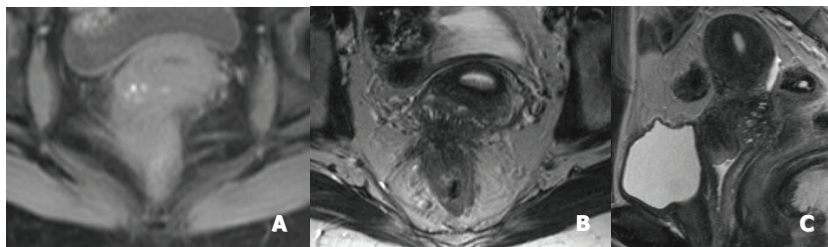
T1-weighted image with fat suppression demonstrates isointensity of the nodule and some small hyperintense foci, suspected for micro-haemorrhages (A). Axial (B) and sagittal (C) T2-weighted image show obliteration of retrouterine excavation by an hypointense nodule, with anterior attraction of the rectum toward the torus uteri and asymmetric thickening of the rectal wall.
